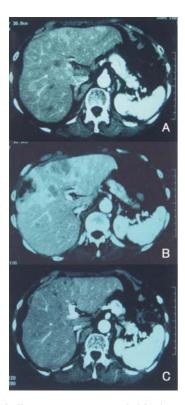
Multiple liver tumors were revealed in the arterial phase of a dynamic computed tomograhic scan (A), which became massive before the start of chemotherapy using hepatic arterial infusion. (B). After the end of the first round of chemotherapy, the massive liver tumors almost completely disappeared, and no new lesions were visible (C).
